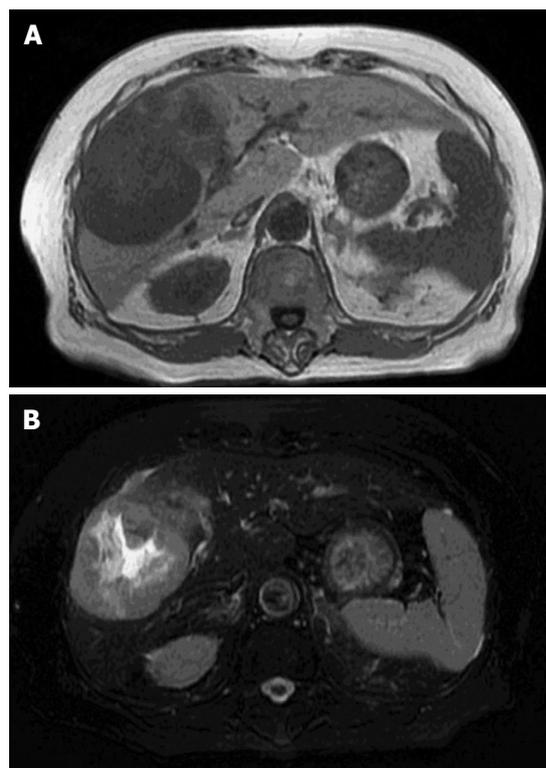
The axial T1-weighted gradient-echo image showed a hypointense mass in the right anterior segment of the liver (A), and the axial T2-weighted spin-echo image with fat suppression showed an isointense mass with a large central hyperintense area (B).
